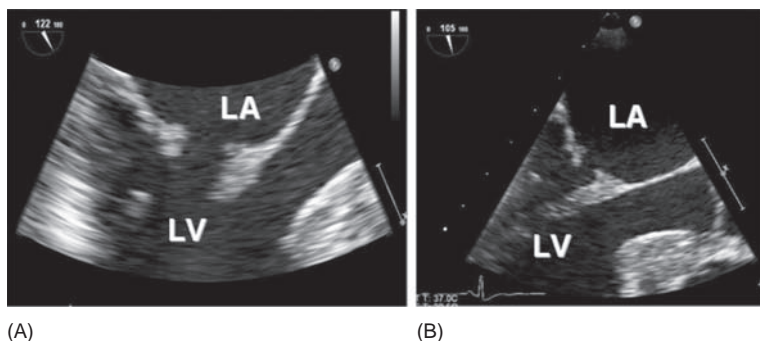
Transesophageal echocardiogram demonstrating vegetations (Libman-Sacks endocarditis) on the atrial aspect of anterior and posterior mitral valve leaflets in a patient with systemic lupus erythematosus. Panel A is a zoom view of the valve leaflets whereas Panel B shows a less detailed image of the leaflets. LA, left atrium; LV, left ventricle.
